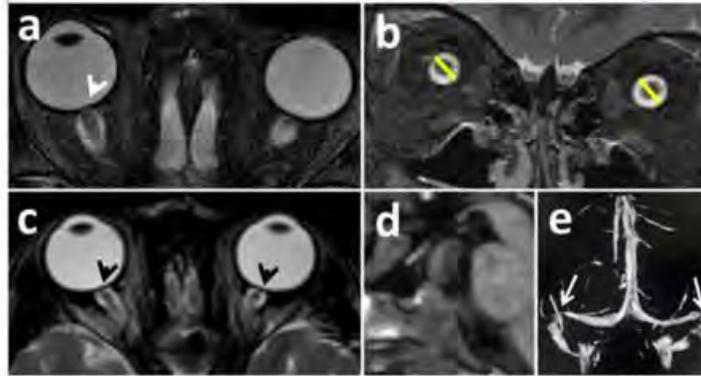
MRI and MRV images of patients with increased intracranial pressure: (a) Axial T2 weighted image shows papilledema on the right side (white arrow head); (b) Coronal T2W image shows bilateral optic nerve sheath distention (The yellow lines demonstrate the wall-to-wall measurements of the optic nerve sheaths diameters); (c) Axial T2 weighted image shows bilateral posterior globe flattening (black arrow heads); (d) Sagittal T1 weighted image in the midline shows partially empty sella; (e) Coronal MIP views of MRV shows bilateral distal transverse venous sinus stenosis at the junctions of the transverse and sigmoid venous sinuses (white arrows).
